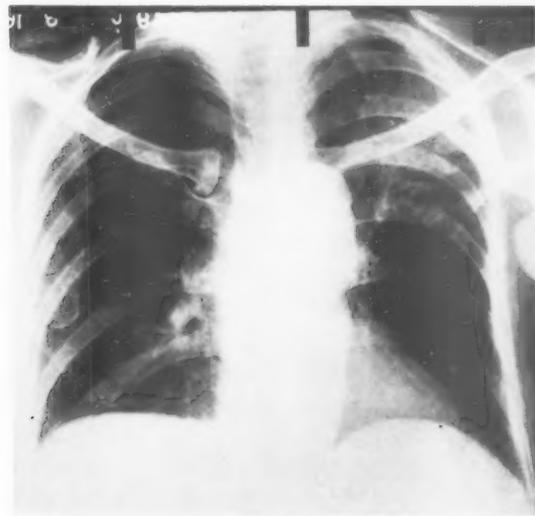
Case 1. Aged sixty-eight. The only case in which fibrosis was found in an otherwise normal lung. Radium had been implanted in axilla at time of operation. No roentgen therapy.
